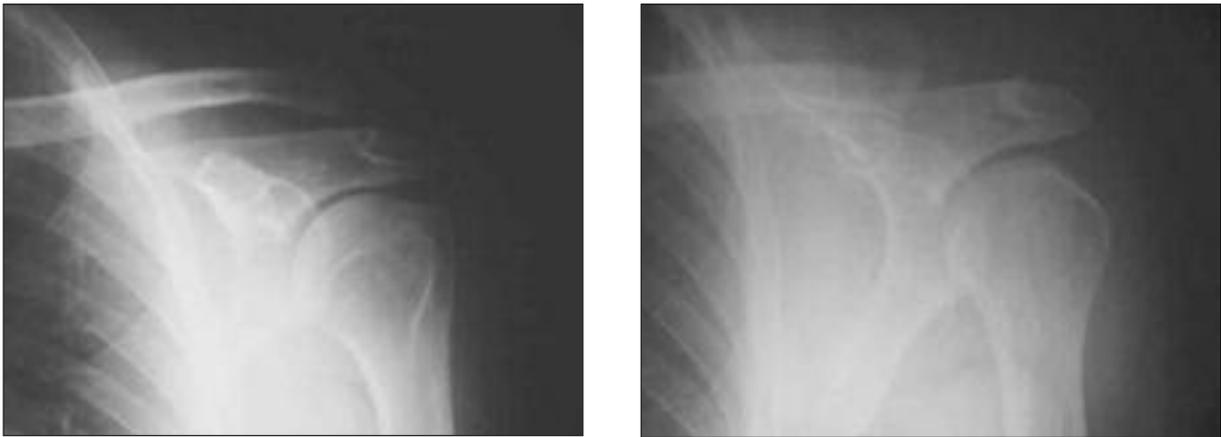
Pre-operative (A), and post-operative (B) radiographs of a patient treated with Modified Weaver-Dunn procedure.
